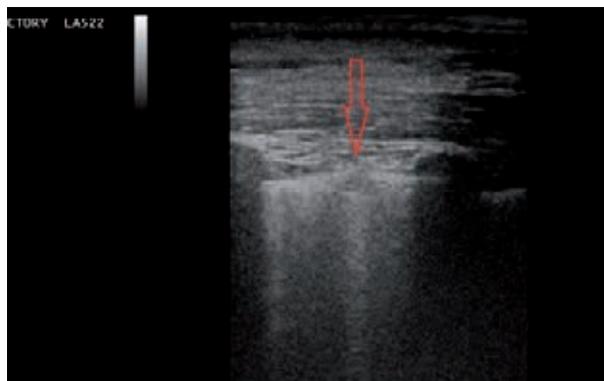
Ultrasound control shows size reduction of lesion.
